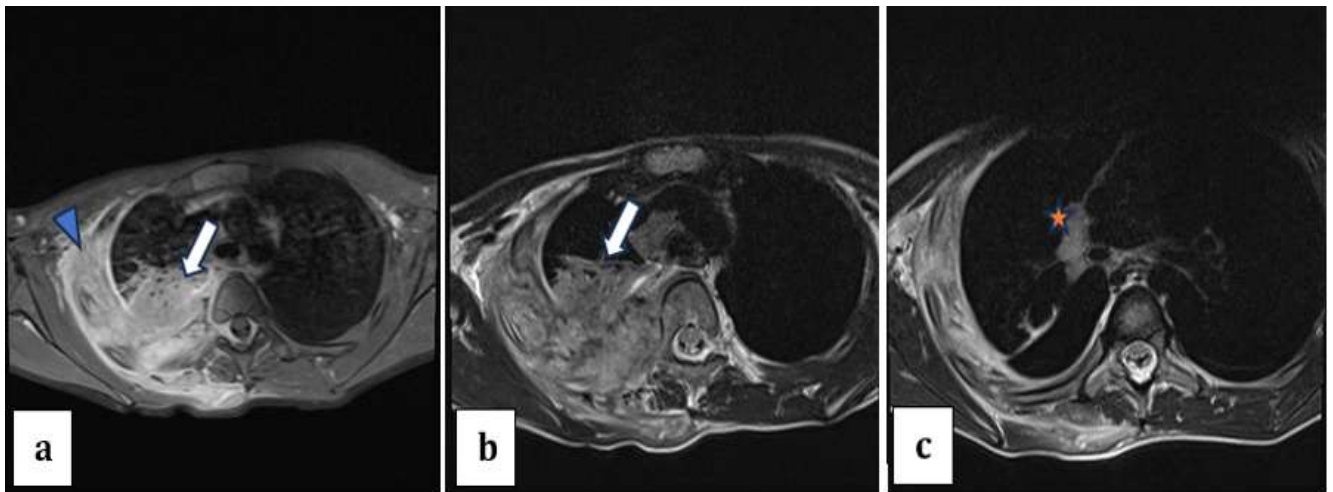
Cervico-thoracic MRI, sequences T1 FS (a) and T2 FS (b, c) showing: an aggressive lesion process infiltrating the right posterolateral upper chest wall (arrowhead) with right pulmonary apico-dorsal condensation (arrow) and right mediastino-hilar adenopathy's (star).
